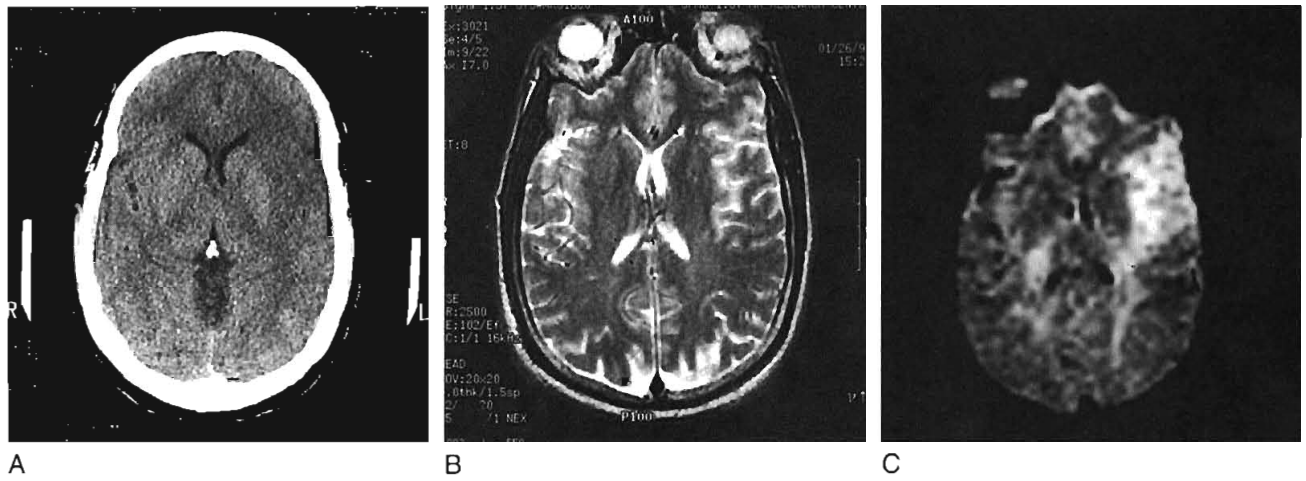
A, Computed tomography scan of the brain in a patient with sudden onset of expressive speech difficulty and right arm weakness 2.5 hours after onset of symptoms. There is early low density and sulcal effacement in the perisylvian region. B, T2-weighted magnetic resonance imaging study of the same patient 5 hours after stroke onset. Subtle increased signal intensity is seen in the perisylvian region. C, Diffusion-weighted image also at 5 hours after stroke onset. A larger area of signal abnormality is present in the left hemisphere.
